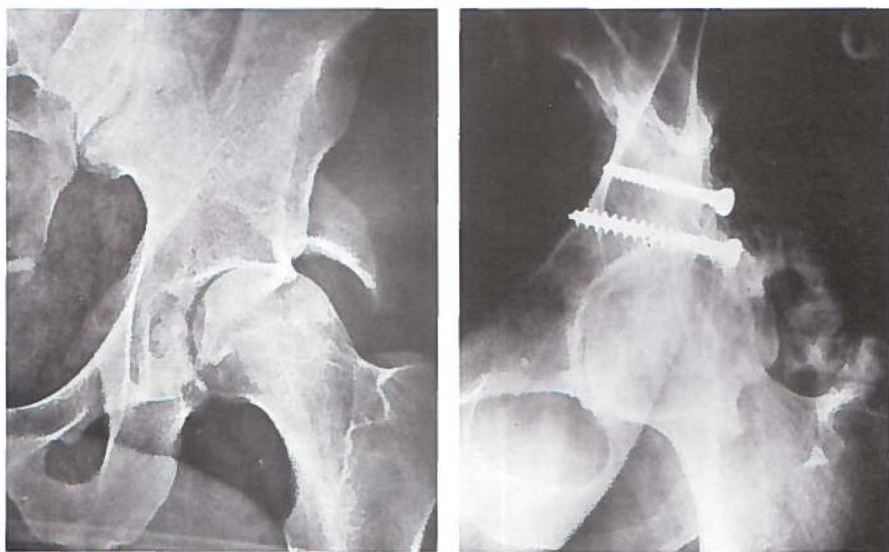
(left). Posterior fracture-dislocation of the hip, with a transverse acetabular fracture, and a rim fracture of the posterior wall. There is minimal comminution. After reduction of the dislocation, the hip was stable, but the weight-bearing dome could not be reduced on traction. Figure 2 (right). Eight years after open reduction and internal fixation there was an excellent clinical and radiographical result.
